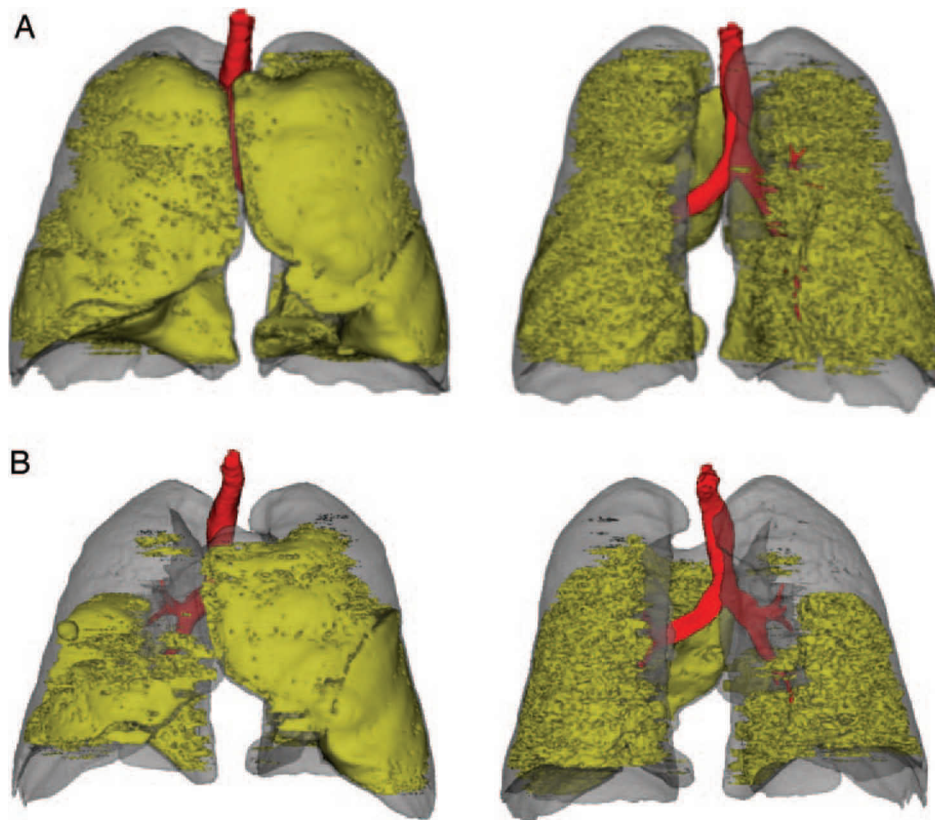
3D rendering of CT scan in inspiration (*top*, A) and expiration (*bottom*, B) with tracheobronchial tree (red), lungs (gray) and large emphysema cluster (class 4; yellow). View from anterior (left) and posterior (right).
